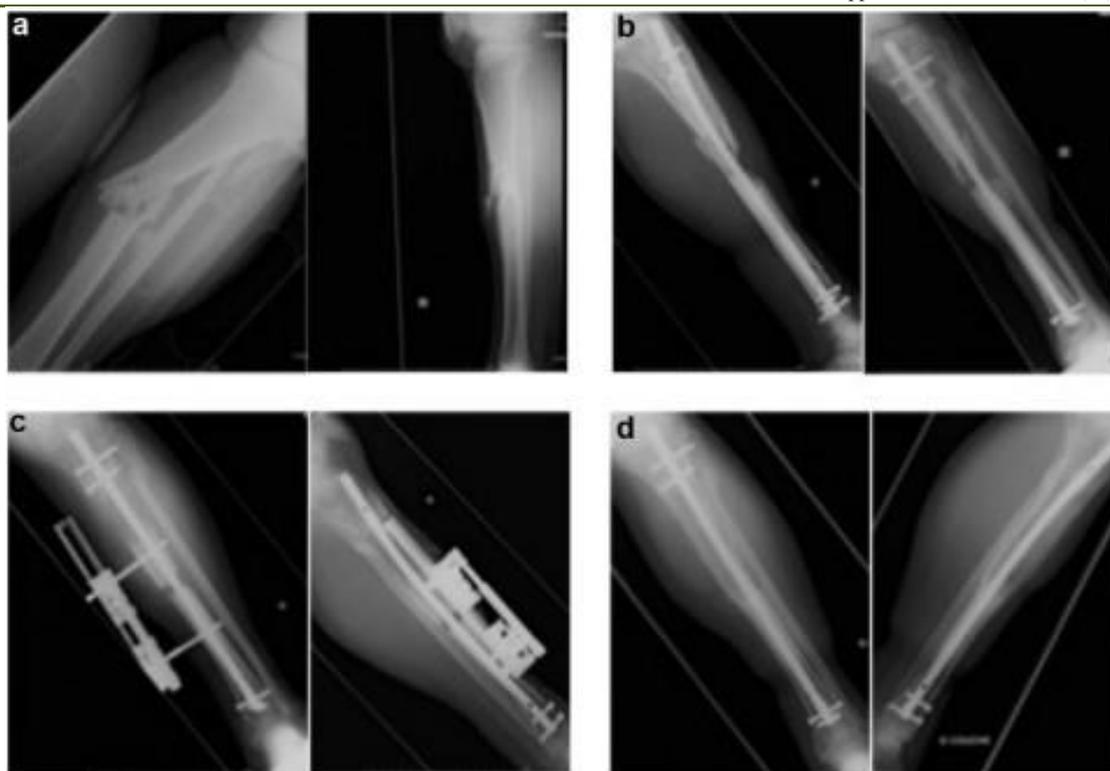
Gustilo type III-B open tibial shaft fracture: bone transport with intramedullary nailing at 6 months. Preoperative radiograph (a). Two months postoperative radiograph (b). At 4 months, segmental bone translocation was performed using intramedullary nailing and a monoplanar external fixator (c). Complete bone healing after 15 months (d)
